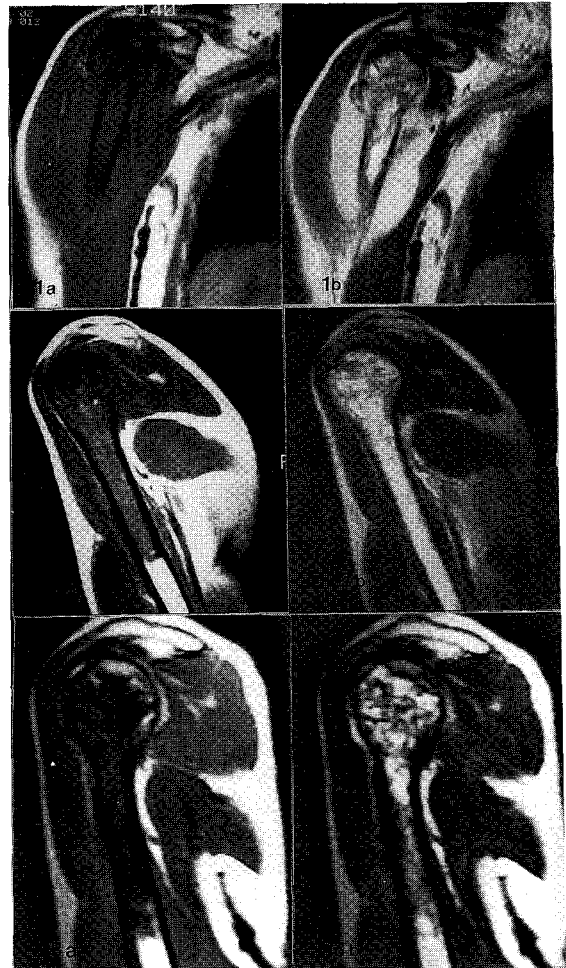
1a and 1b were the T1 and T2 weighted MR images prior to the therapy, which the patient had bone lymphoma in the right humerus. There were abnormal findings involving bone marrow and surrounding soft tissue. 2a and 2b were those during the therapy, 3a and 3b were those after completion of the therapy. There were abnormally changed findings representing decreased size of soft tissue tumor, fat replacement and fibrosis.
